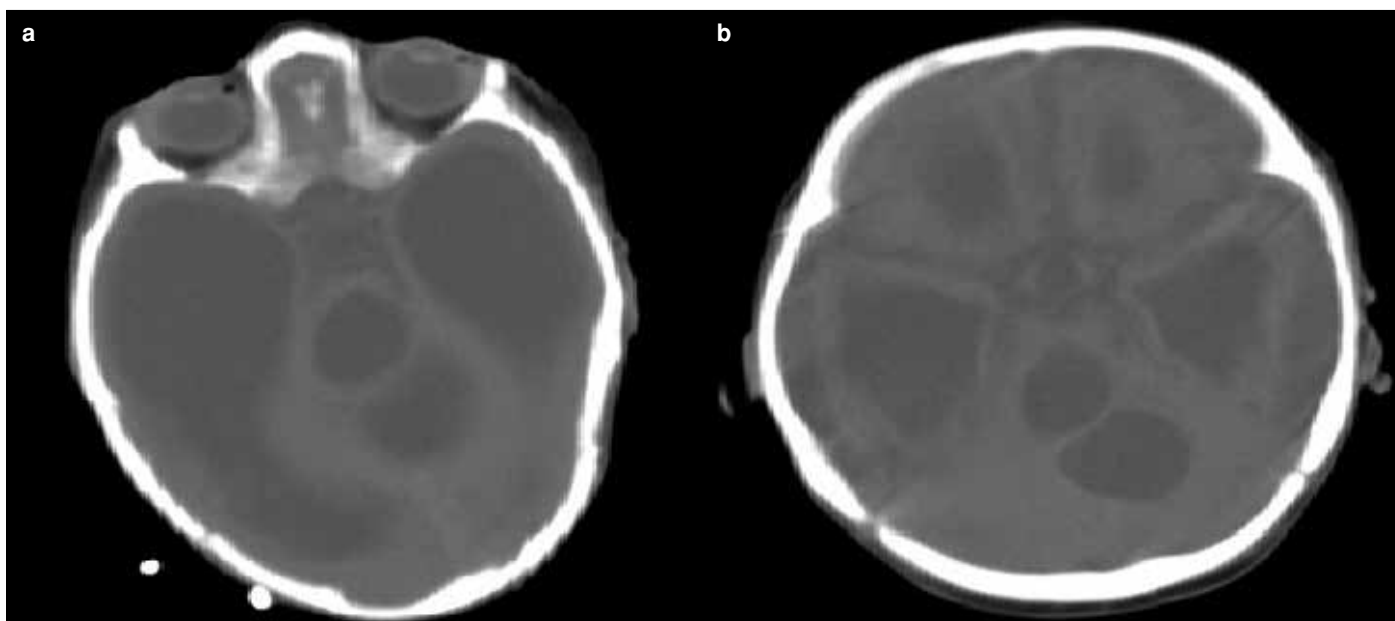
a, b. His imaging findings on admission; on admission, cranial CT showed tetra-ventricular hydrocephalus and hypodense cyst compressing third and fourth ventricle minimally (a); and after treatment cranial CT showed decrease of hydrocephalus and cyst compared to cranial CT findings before the treatment (b)
